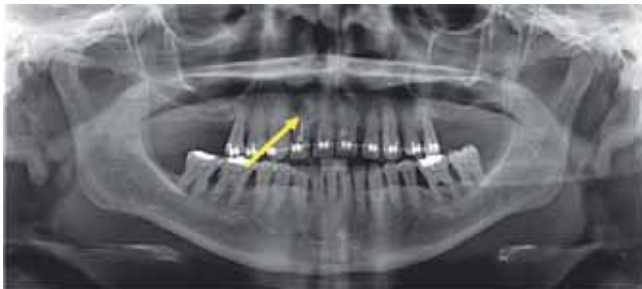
Pre-surgical panoramic radiograph. Tooth 12 shows root canal treatment with periapical lesion.
